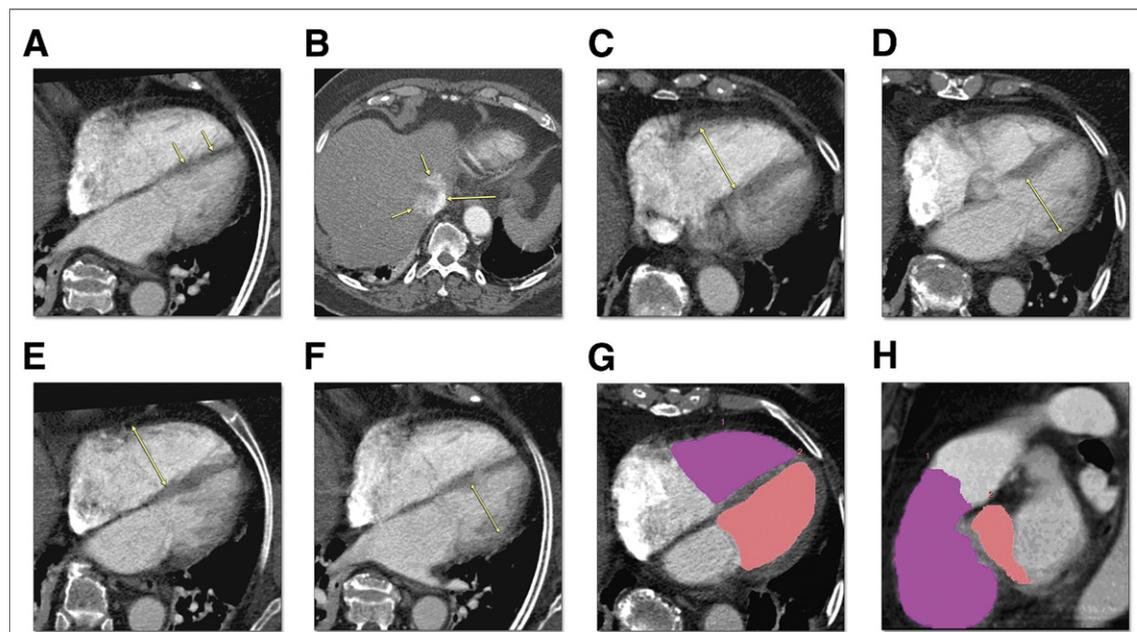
Computed Tomography Signs of RV Dysfunction in a 77-Year-Old Woman
